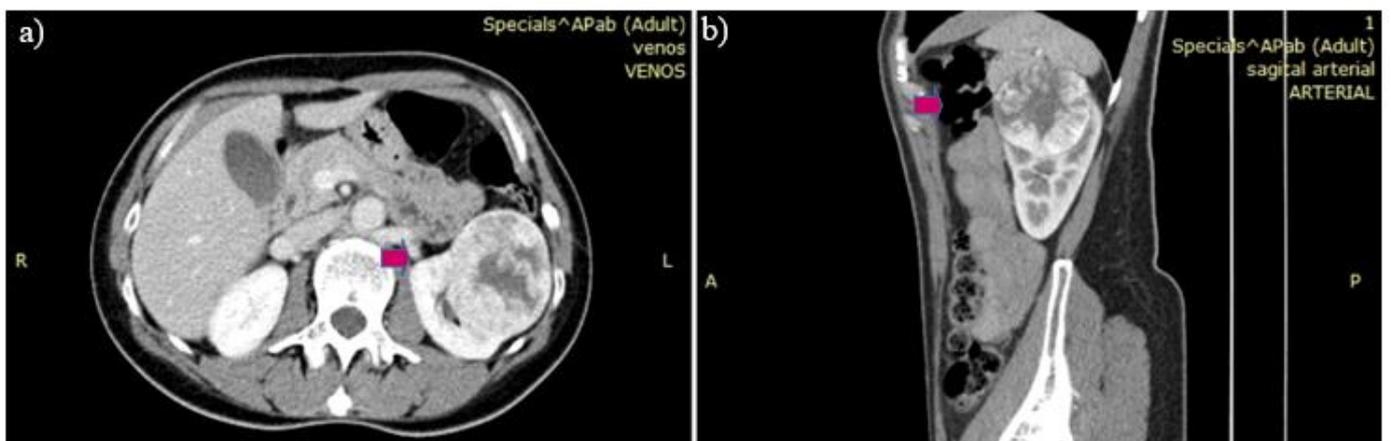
Contrast-enhanced CT a) transversal b) sagittal plane: mediorenal tumor mass (6x5.7x5.6 cm) with non-enhancing (necrotic) areas
